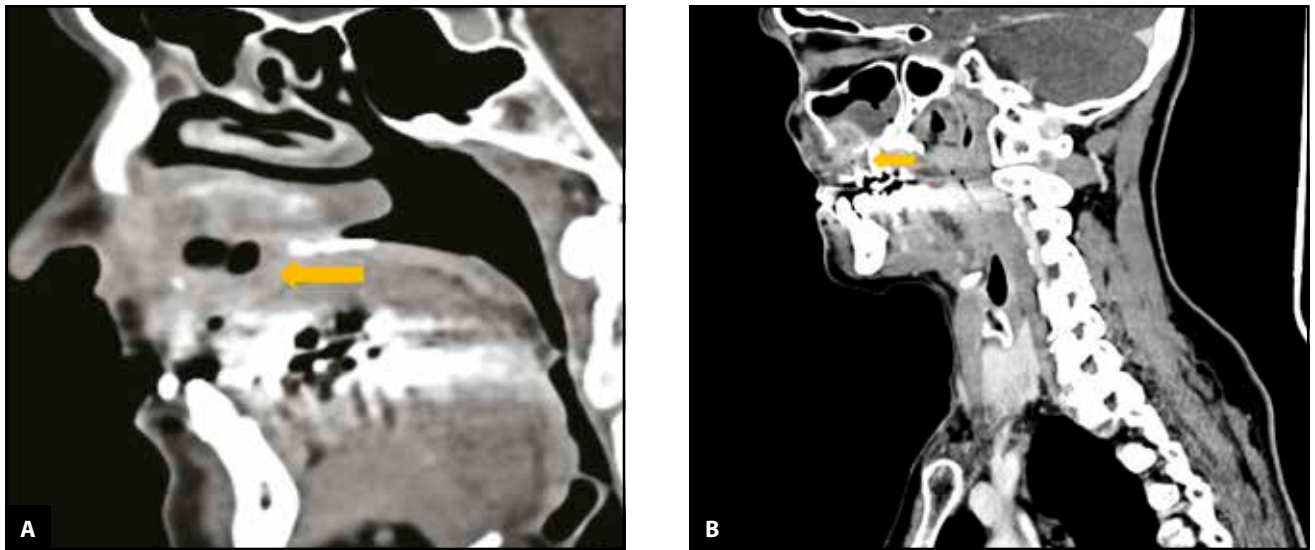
Contrast-enhanced cranio-facial CT scan (A) and neck CT scan (B), right paramedian sagittal sections – tumor invading the hard palate with lysis in the anterior portion (yellow arrow).
